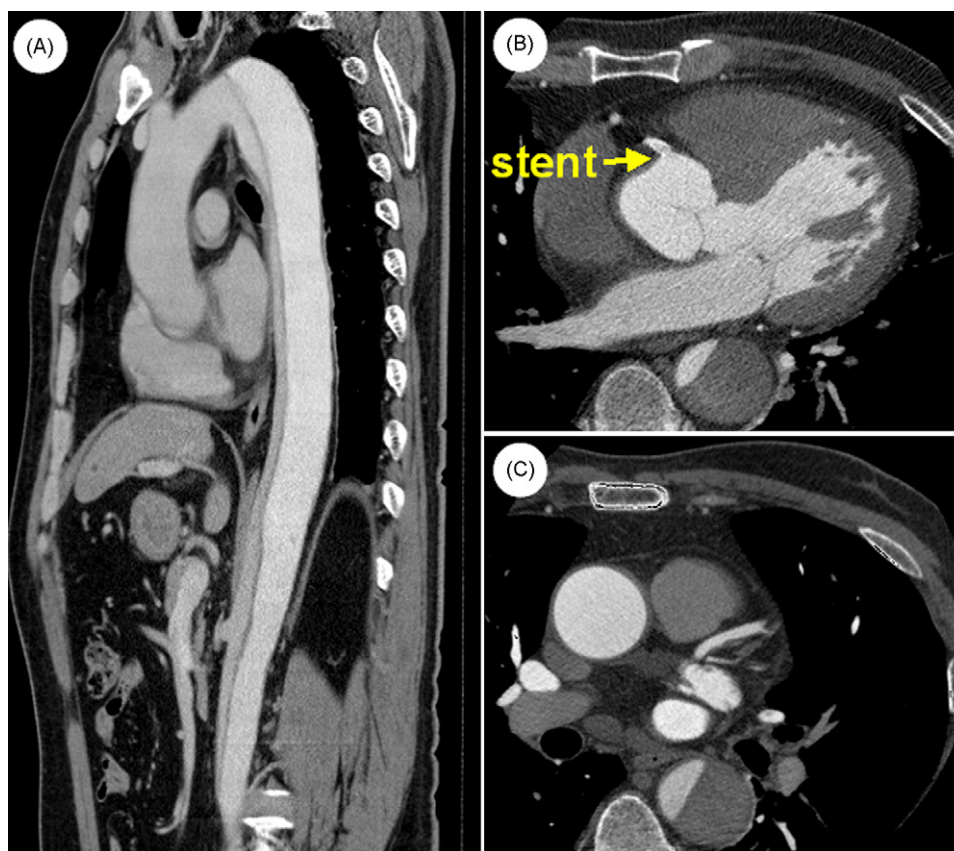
Images obtained by a 64-multislice computed tomography (CT) one year later. (A) An image shown in the sagittal view. (B) The implanted bare metal stent (arrow) was observed clearly at the level of the right coronary cusp. (C) A CT scan showing complete resorption of the ascending aortic intramural hematoma, and showing a descending aortic intramural hematoma.
